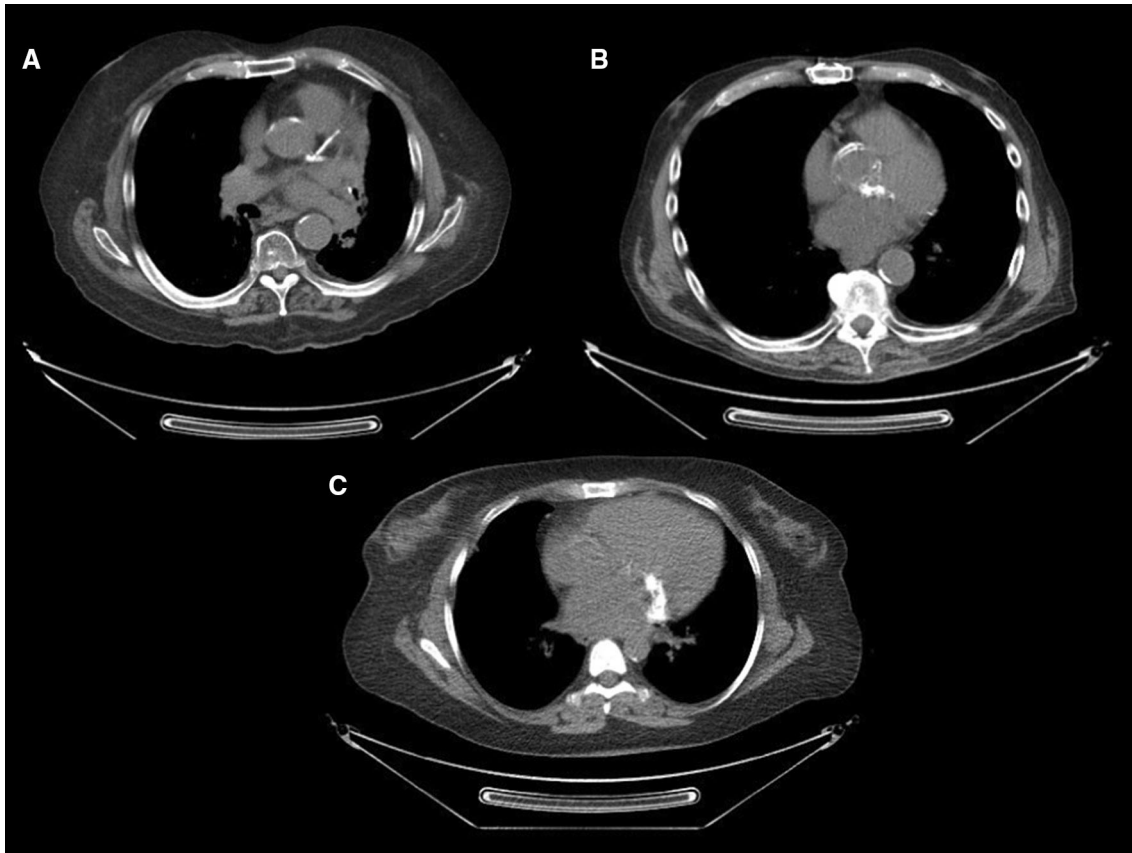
Attenuation correction computed tomography axial images from three patients with prior thoracic irradiation undergoing positron emission tomography/computed tomography myocardial perfusion imaging. (A) Extensive atherosclerotic calcification of left main artery, and proximal left anterior descending and left circumflex arteries, in addition to calcification of the aortic root and descending thoracic aorta. (B) Extensive atherosclerotic calcification of the aortic root is evident on this ungated attenuation correction computed tomography axial image. (C) Prominent mitral annular calcification is present.
